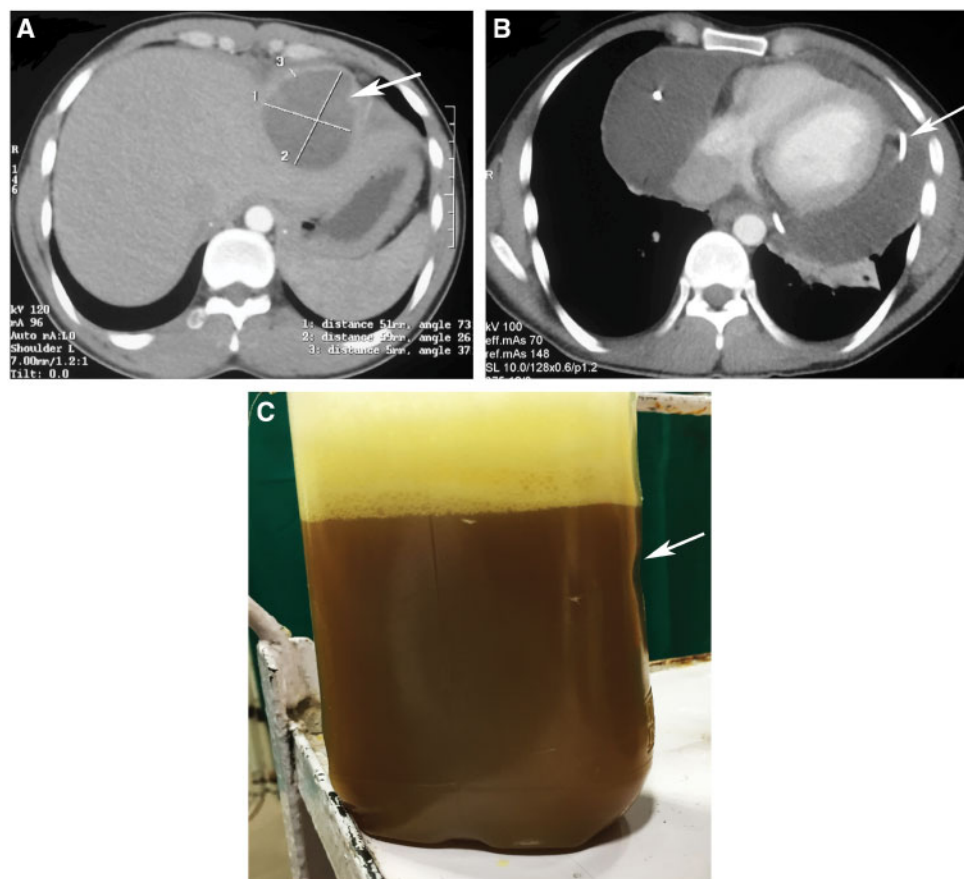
(A) Computed tomography showing an abscess of  $\sim 5 \times 6$  cm in left lobe of the liver (arrow); (B) computed tomography showing massive pericardial effusion with pericardial catheter in situ (arrow) and (C) reddish-brown chocolate coloured pus obtained after therapeutic pericardiocentesis (arrow).
